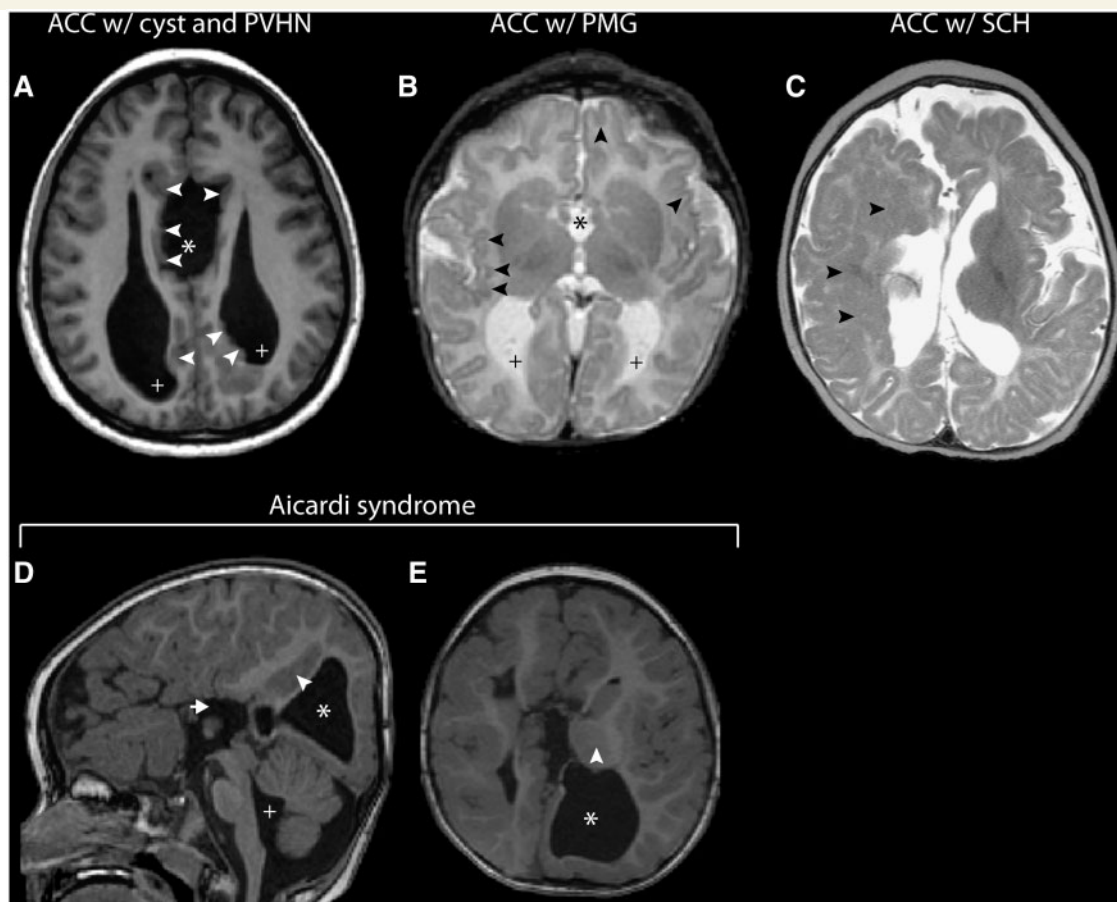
Associated malformations commonly seen in patients with ACC. (A) T₁-weighted axial MRI scan showing complete ACC associated with a third ventricle cyst (asterisk) and periventricular nodular heterotopia (arrowheads). (B) T₂-weighted axial MRI scan showing ACC (asterisk) associated with polymicrogyria (PMG) (arrowheads) and colpocephaly (+). (C) T₂-weighted axial MRI scan showing ACC with subcortical heterotopia (SCH) (arrowheads) and marked asymmetry of the cerebral hemispheres. Midsagittal (D) and axial (E) T₁-weighted MRI scan of a patient with Aicardi syndrome revealing a constellation of neuroradiological features, including complete ACC (arrow), grey matter heterotopia (white arrowhead), cystic dilation of the left lateral ventricle (asterisk) and enlarged fourth ventricle (+). In addition, there is marked asymmetry of the cerebral hemispheres.
